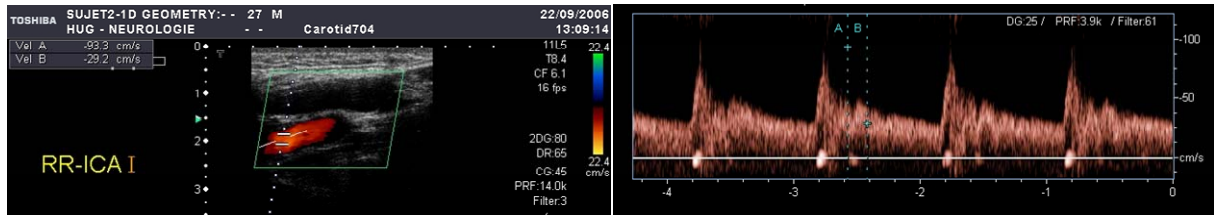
Longitudinal cross section of the vessel and ultrasound beam (left). Typical peak velocity, of 4 consecutive heart cycles, measured in the internal carotid artery.
